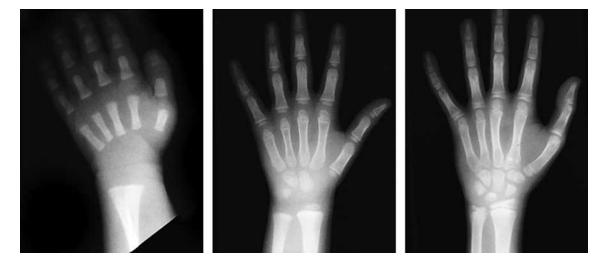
Increasing numbers of ossification centers become radiographically visible with age. From left, the hands shown are those of a toddler, a young school-age child, and a young adolescent. Injuries affecting unossified bones or growth centers are invisible radiographically.
